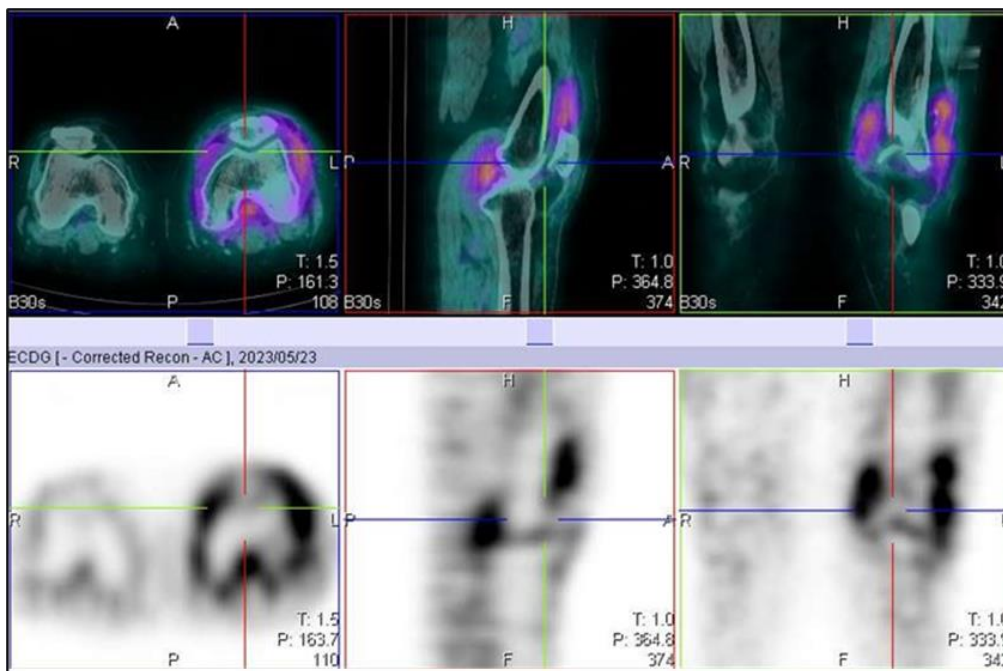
^{99m}Tc -glucosamine SPECT/CT and SPECT images of the knee of a 51-year-old female showing abnormal increase uptake of the radiopharmaceutical in all four regions of the left knee joint. Baseline ultrasound imaging was initially negative for disease in the popliteal, medial and lateral regions of the joint, but positive on subsequent 6 weeks follow-up imaging
